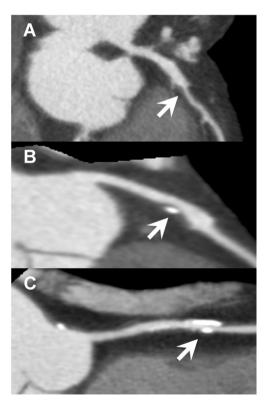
Example of plaque imaging performed on 320-slice multislice computed tomography coronary angiography. (A) Curved multiplanar reconstruction of the left anterior descending artery (LAD) with non-calcified plaque (arrow). (A) Curved multiplanar reconstruction of the LAD demonstrating mixed plaque (arrow). (C) Curved multiplanar reconstruction of the right coronary artery demonstrating calcified plaque (arrow).
